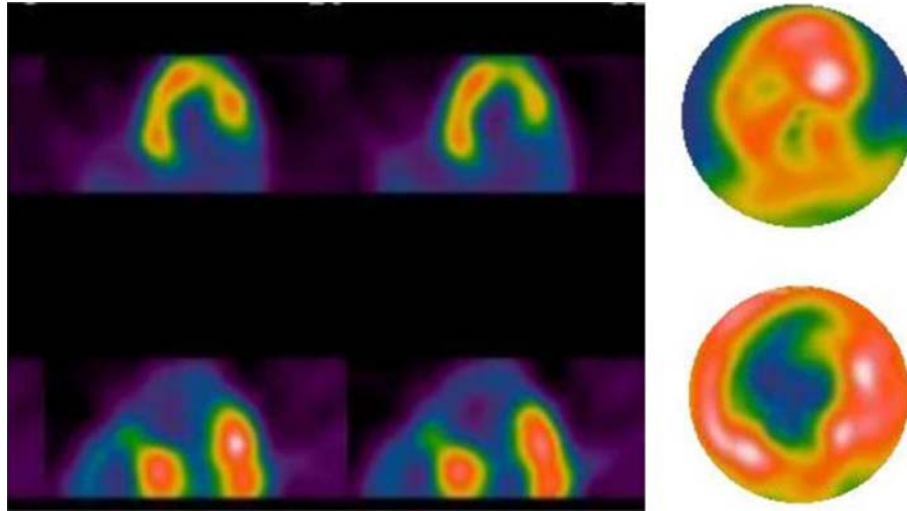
Two horizontal long axis slices and one polar map, bull's-eye display of a PET FDG, above, and a PET Rb-82, below. There is a moderate to large sized, severe defect in the anterior-septal-apical regions on PET Rb-82 that shows a "hot spot," or dramatically more (MISMATCHING) intensity of FDG to indicate that the myocardium is viable, implying a limited extent of scar tissue in the subendocardium, consistent with Figure 1A.
